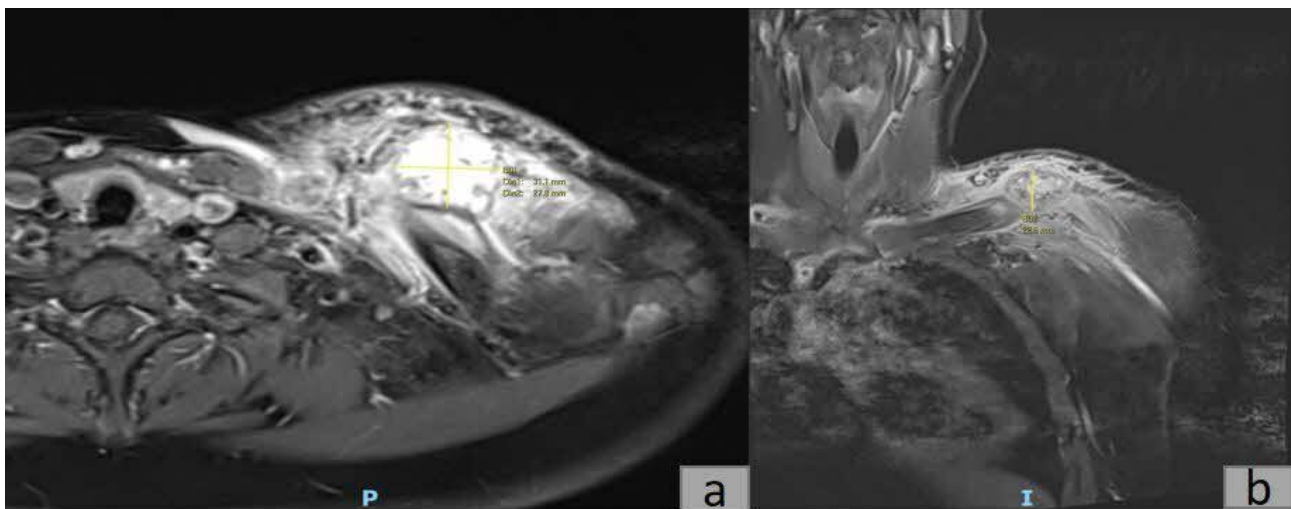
Axial (a) and Coronal (b) T1 weighted magnetic resonance images of a 3.1cm x 2.8cm x 2.3cm lesion in the middle-distal third of the left clavicle
